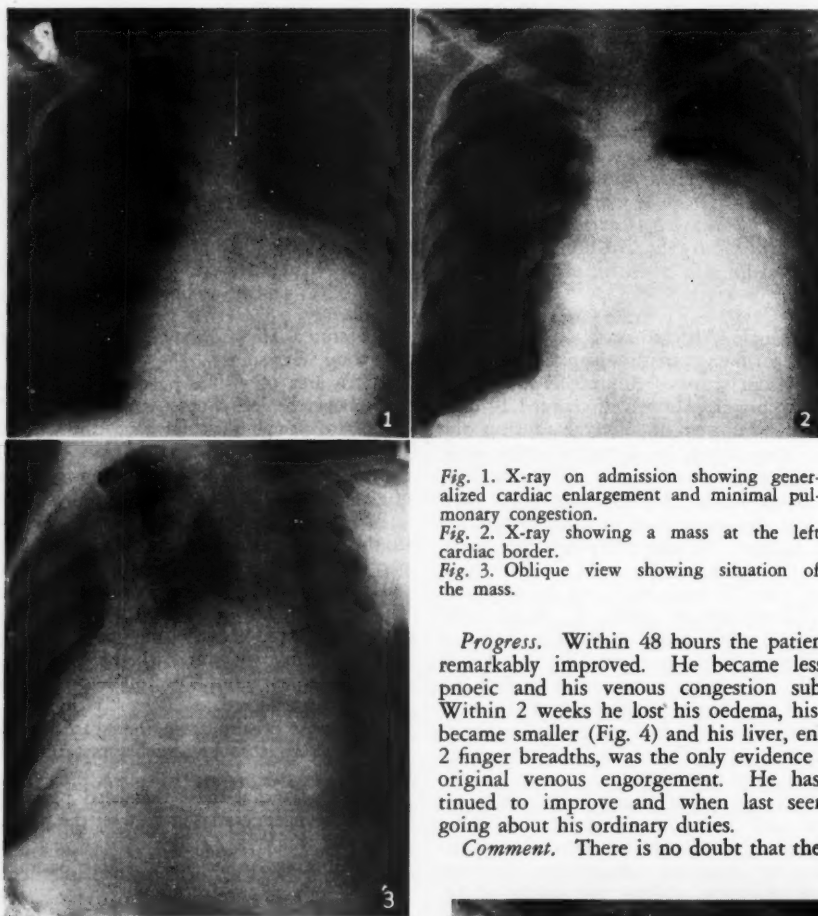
X-ray on admission showing generalized cardiac enlargement and minimal pulmonary congestion.
